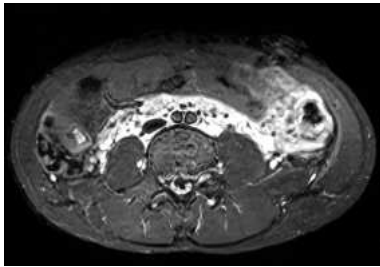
MRI showing uptake in the retroperitoneal region
